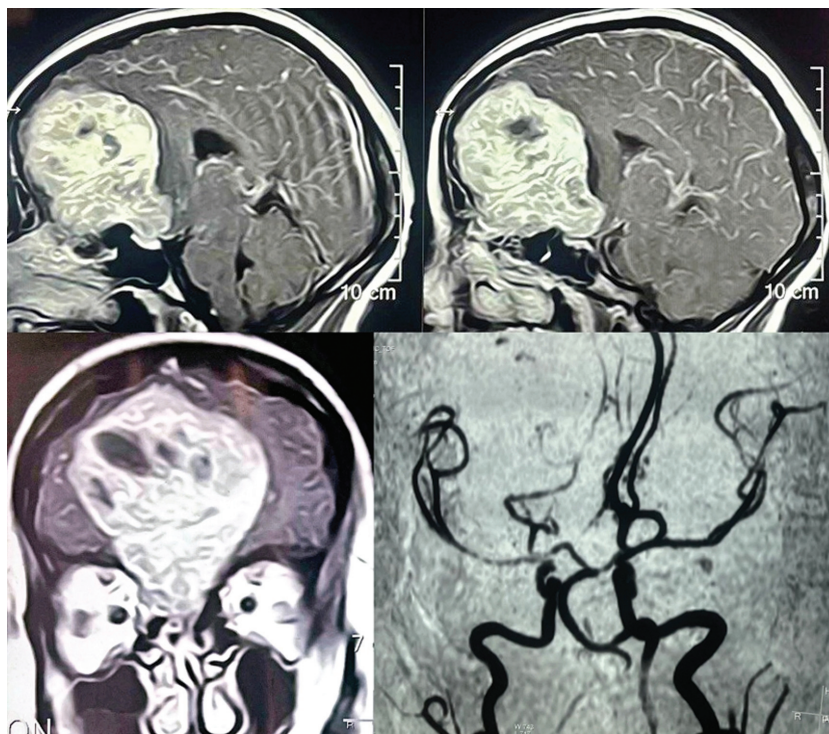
A postcontrast T1-weighted magnetic resonance imaging (MRI) brain, displaying olfactory groove meningioma (OGM) extending through the ethmoidal plate into ethmoidal air cells. Posteriorly and superiorly: it is seen displacing related frontal lobes, genu of corpus callosum posteriorly, and both anterior cerebral arteries (ACAs) to the left side of the lesion.
